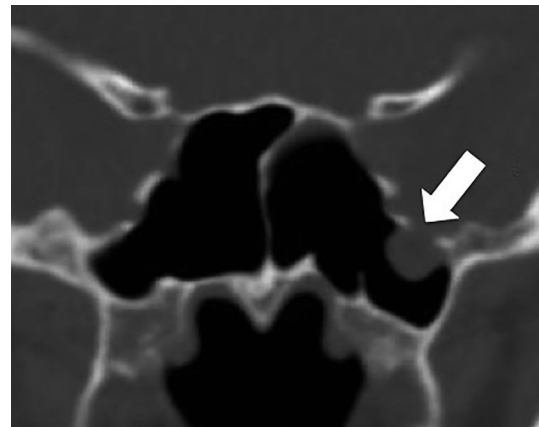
Coronal CT image demonstrating a meningoencephalocele at the roof of the lateral recess of the left sphenoid (white arrow)
